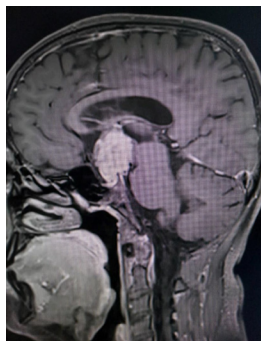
3 MRI T1+Contrast: Homogenous enhancement of lesion.
